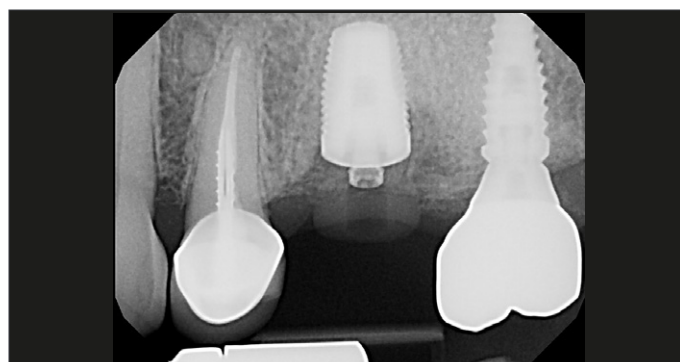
Patient comes back after a healing time of 10 days. Before intra oral scanning an x-ray image is performed of the situation.
